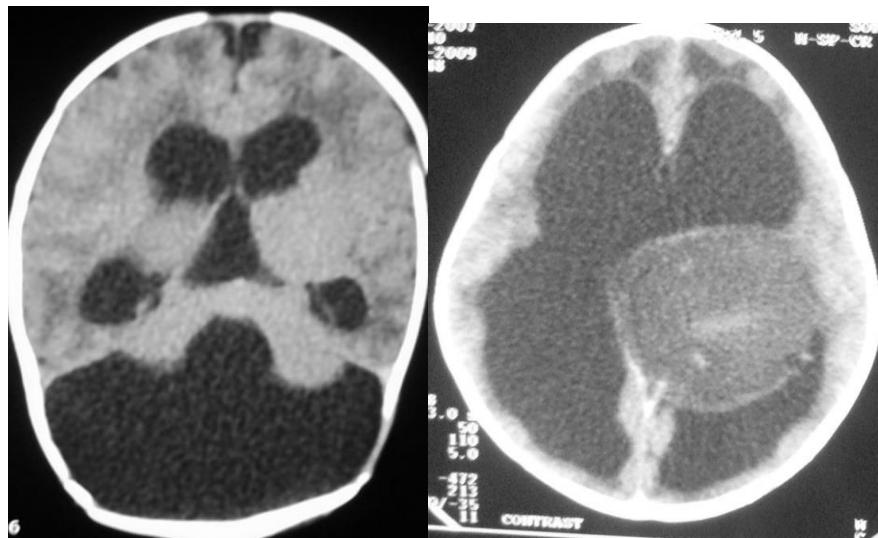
CT scan images. a. Absence of the cerebellum (Dandy-Walker syndrome) with dilated ventricles due to congenital brain anomaly. b. Craniopharyngioma with gross hydrocephalus.
